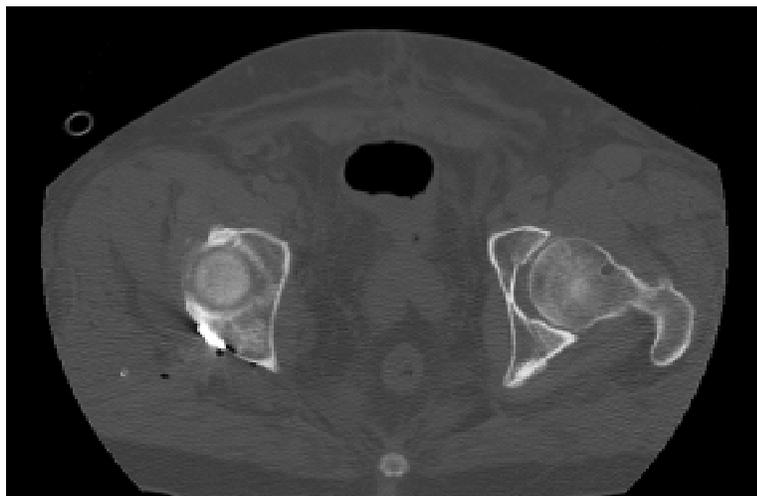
The postoperative pelvic CT scan shows the fracture reduction and implant location. The osteochondral impaction fragment has been elevated and its defect filled with cancellous bone graft.
